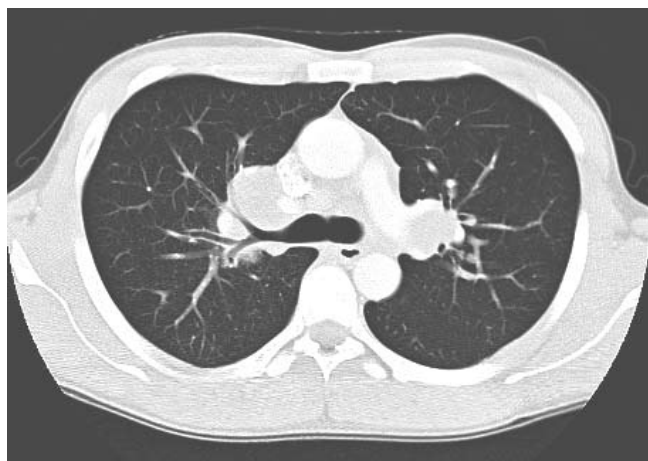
CT chest demonstrating bilateral hilar adenopathy.
